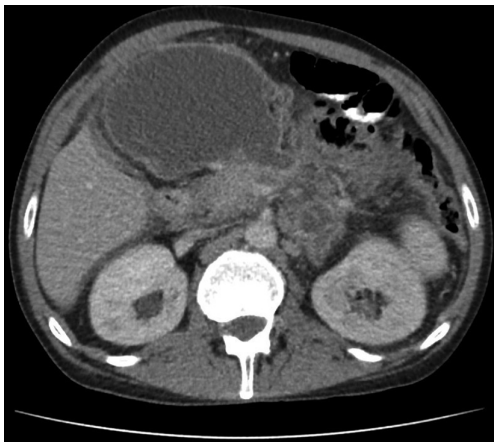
Initial computed tomography scan demonstrating peripancreatic necrotic collections prior drainage.
